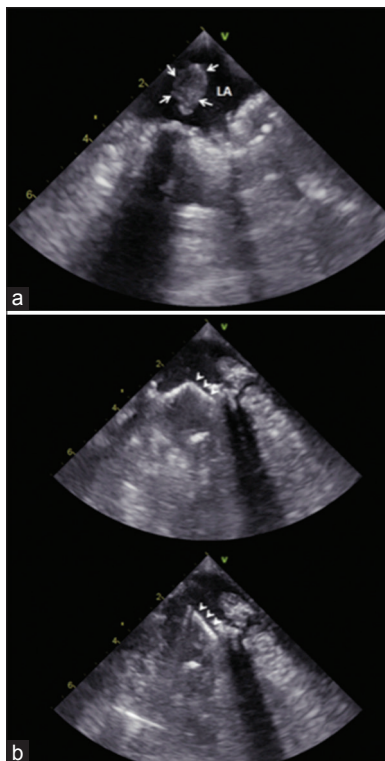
(a) First intraoperative transesophageal echocardiography showed freely mobile large thrombus in the left atrium (arrows) and (b) second intraoperative transesophageal echocardiography revealed immobile mitral valve leaflet (arrowhead)
